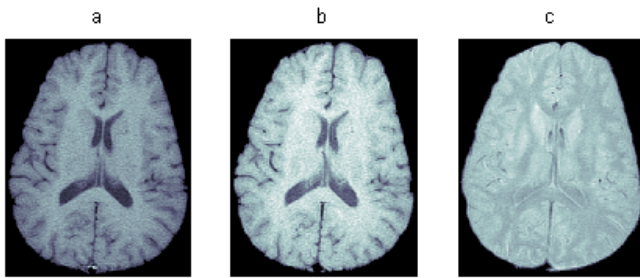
Clinical Spin-Echo MR images - From left to right: (a) Tr=500, Te=8 (b) Tr=500, Te=20 (c) Tr=2400, Te=20 All times in [msec].
